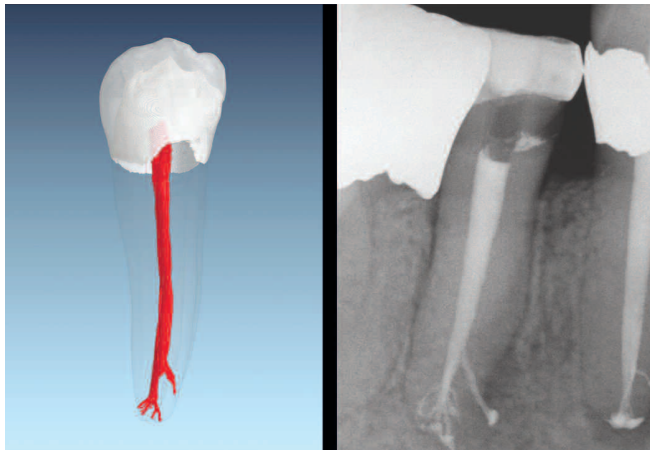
Left: A μ CT image of a mandibular bicuspid (Courtesy of Dr. Frank Paque; Zurich, Switzerland). Right: A post-treatment film demonstrates that a well-shaped canal promotes 3D cleaning and filling root canal systems.
